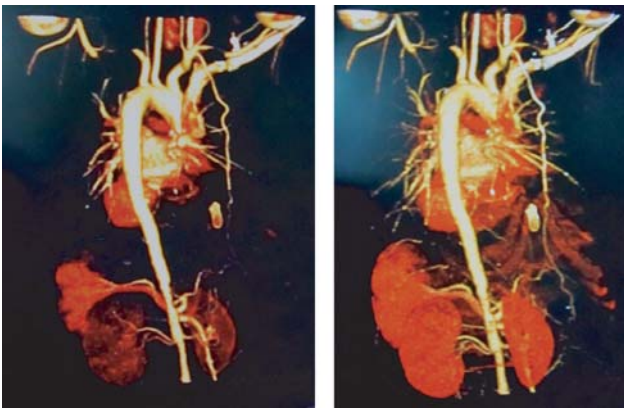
CT angiogram of abdominal aorta
